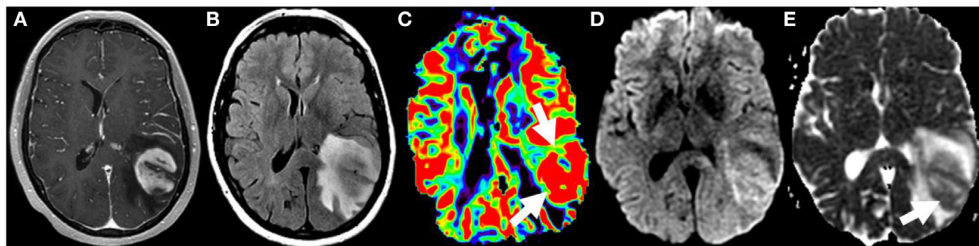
Preoperative GBM imaging. Axial contrast-enhanced T1 (A), and T2 FLAIR (B) scans show a heterogeneously enhancing tumor mass in the left parietal lobe with extensive edema. Elevated relative cerebral blood flow (white arrows) on the perfusion weighted image (C) indicates higher vascular density. Diffusion MRI maps (D, E) reveal hypercellular areas of restricted water diffusion [48].
